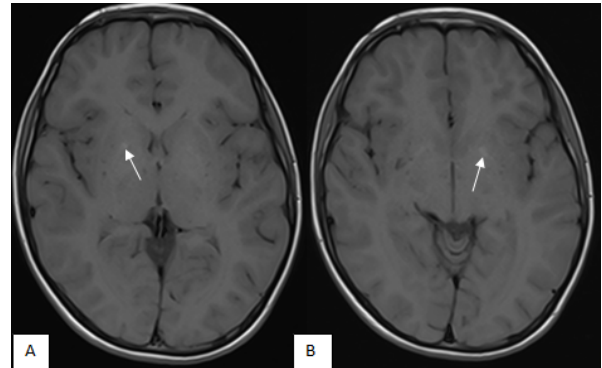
Axial T1w MRI of brain show faint T1w shortening effect of calcifications on the right (A, arrow) and left (B, arrow) globus pallidum
